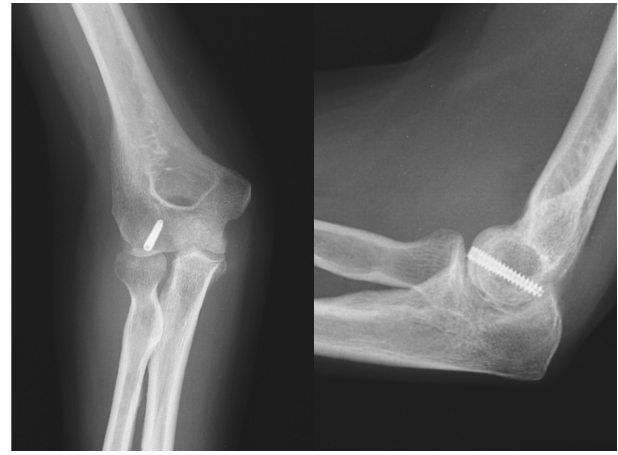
X-ray after 1 year showing the fracture consolidation without signs of AVN, heterotopic ossifications and secondary osteoarthritis
